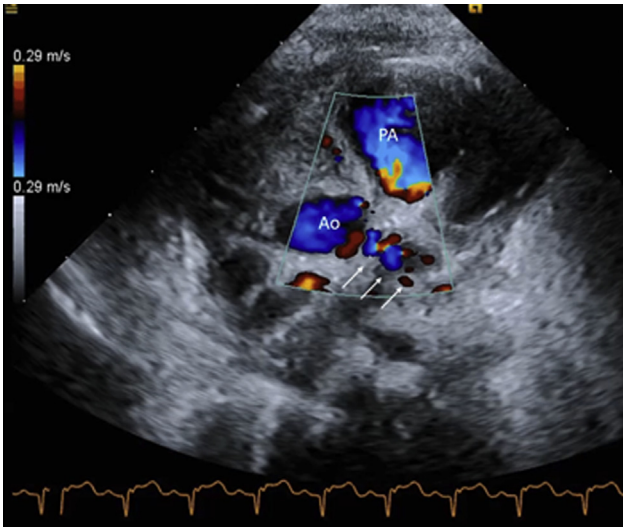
Short-axis imaging at the level of the aortic root demonstrates anterograde filling by color Doppler in the dilated left main coronary artery (arrows). The pulmonary artery (PA) is seen anteriorly. Ao, Aorta.
